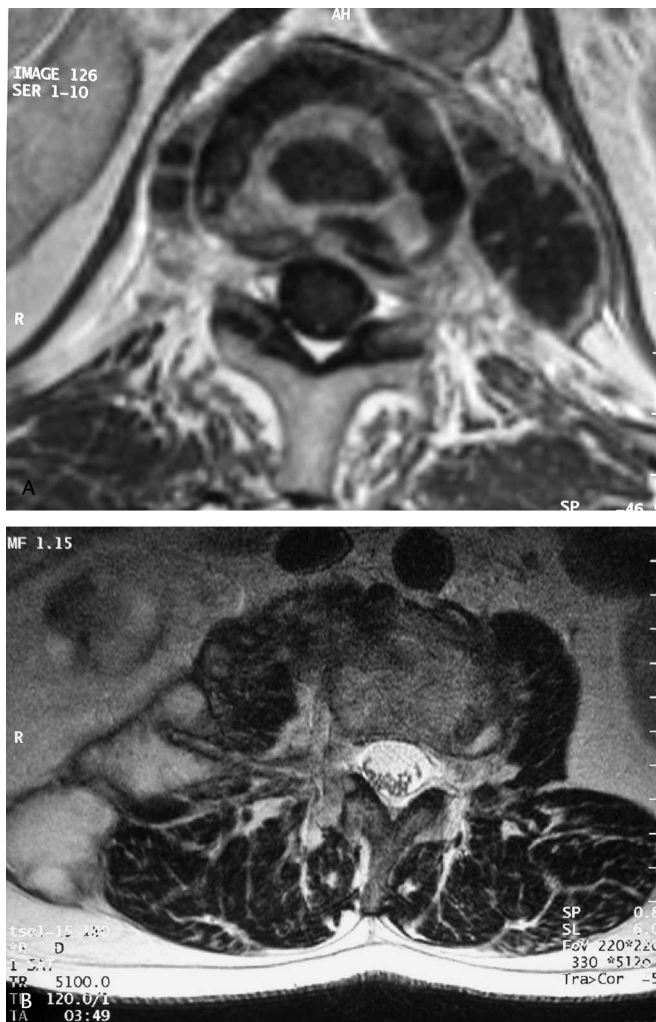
(A) A T1-weighted MRI shows spondylodiscitis of T12 with paraspinal abscess. (B) A T2-weighted image shows the extent of the paraspinal abscesses.
